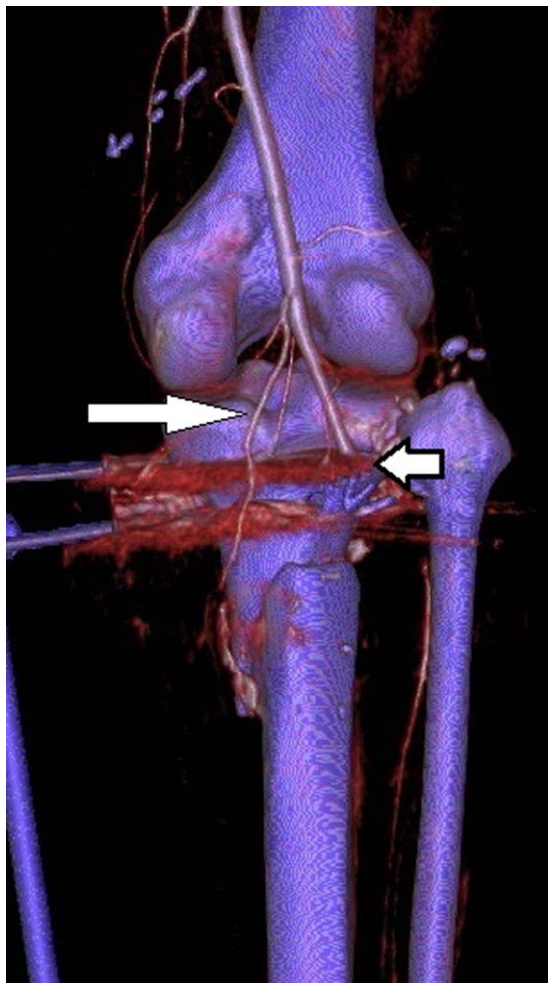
CT angiogram of lower extremity. White small arrow shows disruption of popliteal artery with loss of visualization of posterior tibial vessels. Long white arrow shows the healthy segment of the medial sural artery
